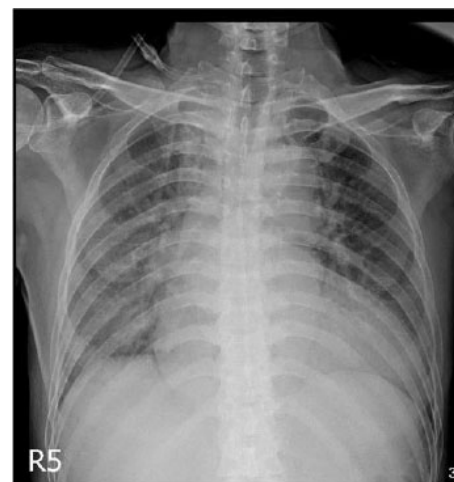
Chest X-Ray: Parahilar and paracardiac consolidation at the right lung, and cardiomegaly.
